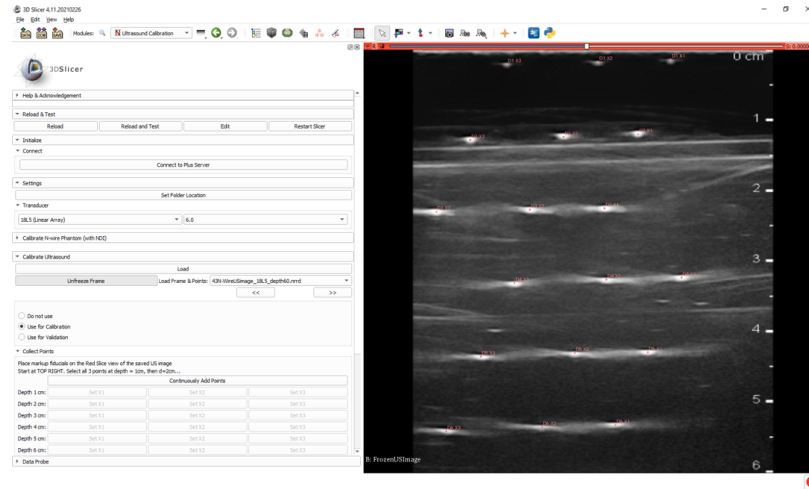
4: Ultrasound calibration module in 3D Slicer.
